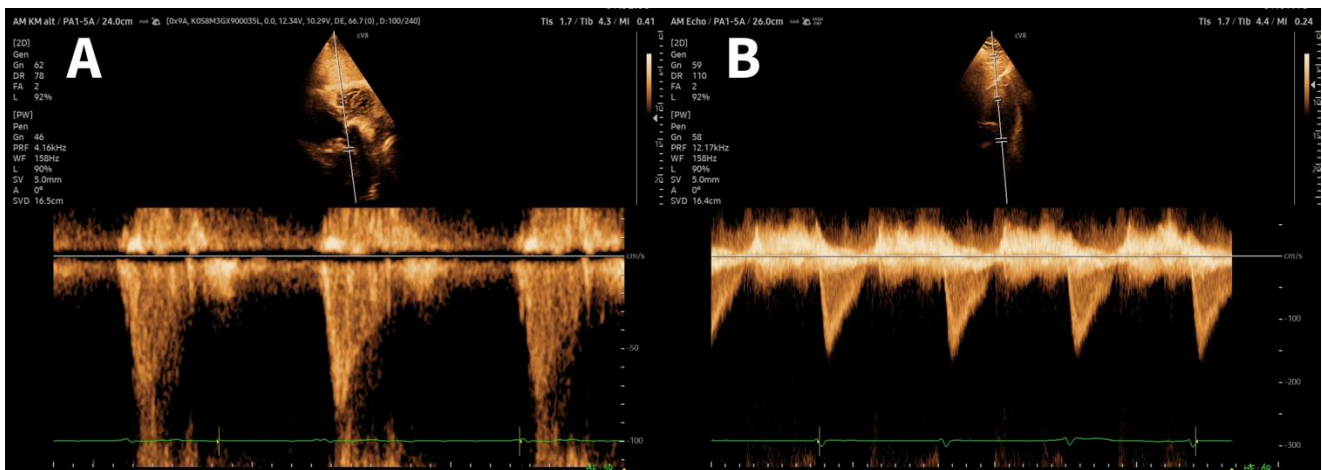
PW-Doppler signals to enhance the quality of the Doppler, a) still over-gained signal, b) optimally adjusted signal. Those are just some examples of the wide possibilities for contrast imaging.
